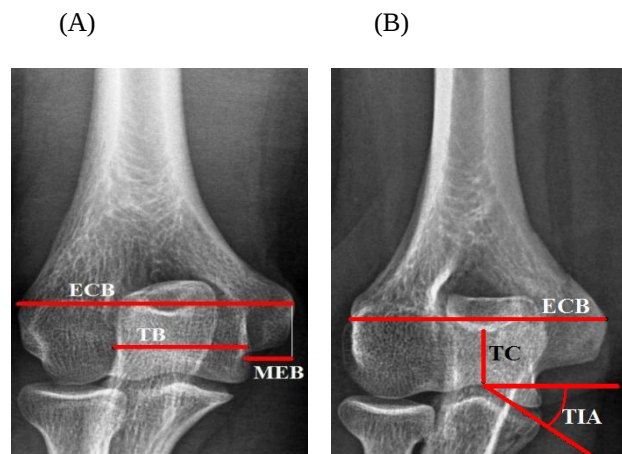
Anteroposterior views of right elbows. A) A male radiograph showing epicondylar breadth (ECB), trochlear breadth (TB) and medial epicondylar breadth (MEB), extending from the edge of trochlea to the tip of medial epicondyle (marked by the vertical white line). B) A female radiograph showing ECB, trochlear constriction (TC) and trochlear inclination angle (TIA)
